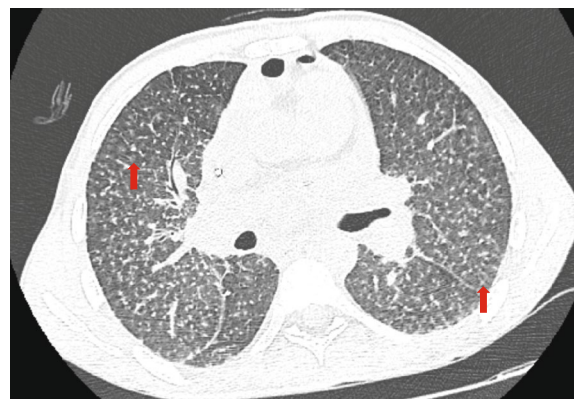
Chest radiograph showing bilateral micronodular infiltrate (red arrows)
